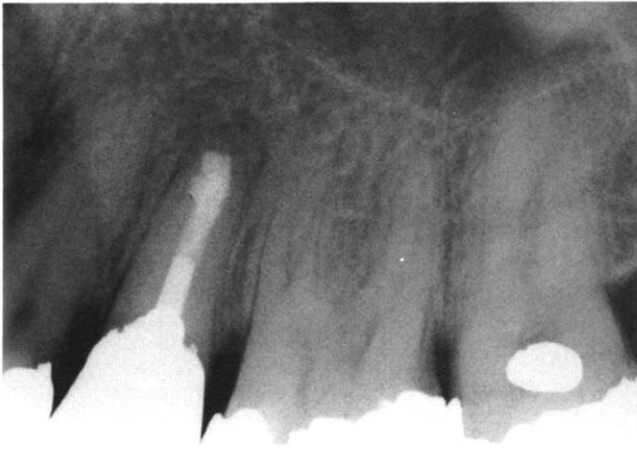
One-year recall radiograph. Note the osseous regeneration and normal periodontal ligament space.
